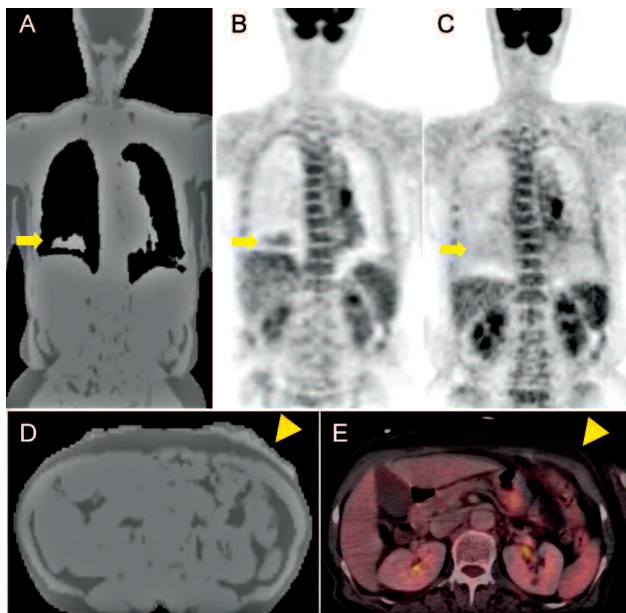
^{18}F -FDG PET/MR study of a 73 years old woman with thyroid cancer. (A) Dixon-based attenuation map depicting erroneous soft tissue segment in supradiaphragmatic area. (B) PET emission image from PET/MR following Dixon-AC using A showing area of false positive uptake. (C) PET emission image from PET/CT following CT-AC showing no abnormal radio-activity. (D) Dixon-based attenuation map depicting erroneous soft tissue segment outside of abdominal skin. (E) PET/CT image corresponding to D showing nothing in there.
